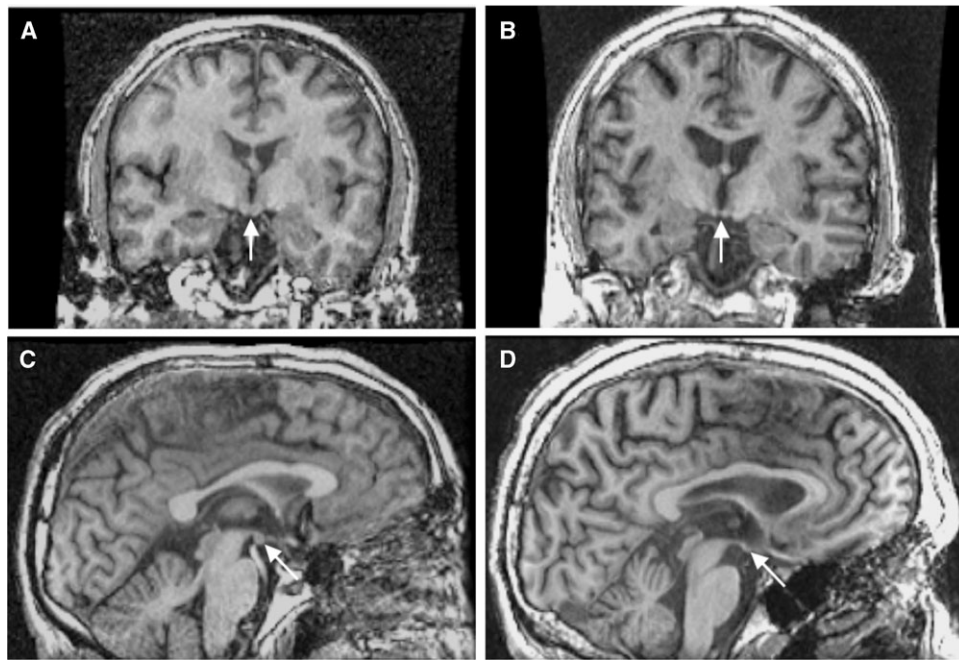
T1-weighted SPGR images of the healthy (left panel) and WKS (right panel) men in Fig. 3. Note the shrunken mammillary bodies (arrows) in the WKS (B and D) compared with the control (A and C).
